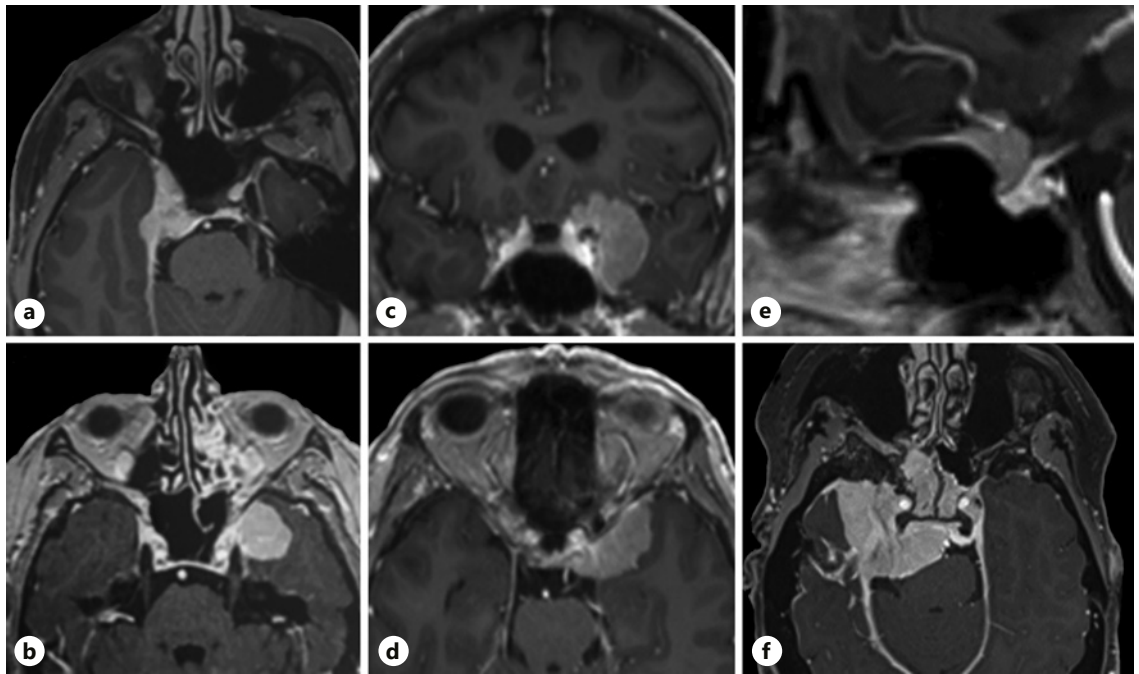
Parasellar meningiomas on T1-weighted MRI with gadolinium enhancement. CS meningioma extending into Meckel's cave (a), CS lateral wall meningioma (b), meningioma arising from the CS lateral wall extending to the lateral and superior aspect of the anterior clinoid process (c), anterior clinoid process meningioma with osteoma of insertion (d), tuberculum sellae meningioma (e), and extensive cavernosphenopetroclival meningioma (f).
